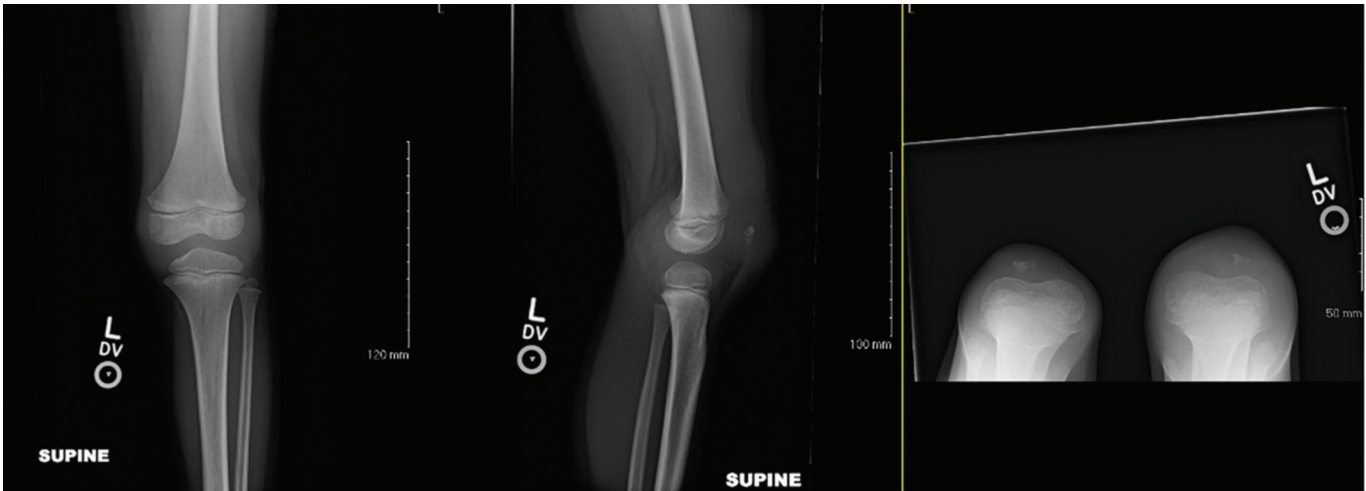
Left knee AP, lateral, and sunrise x-rays demonstrating a large knee joint effusion and further changes in the patella.
